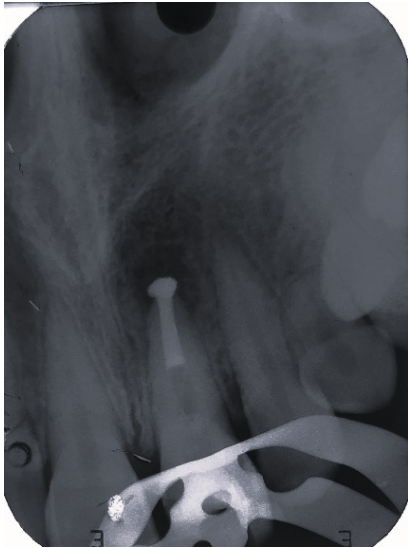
MTA placed in the apical 4-5mm of the canal to form an apical barrier.
